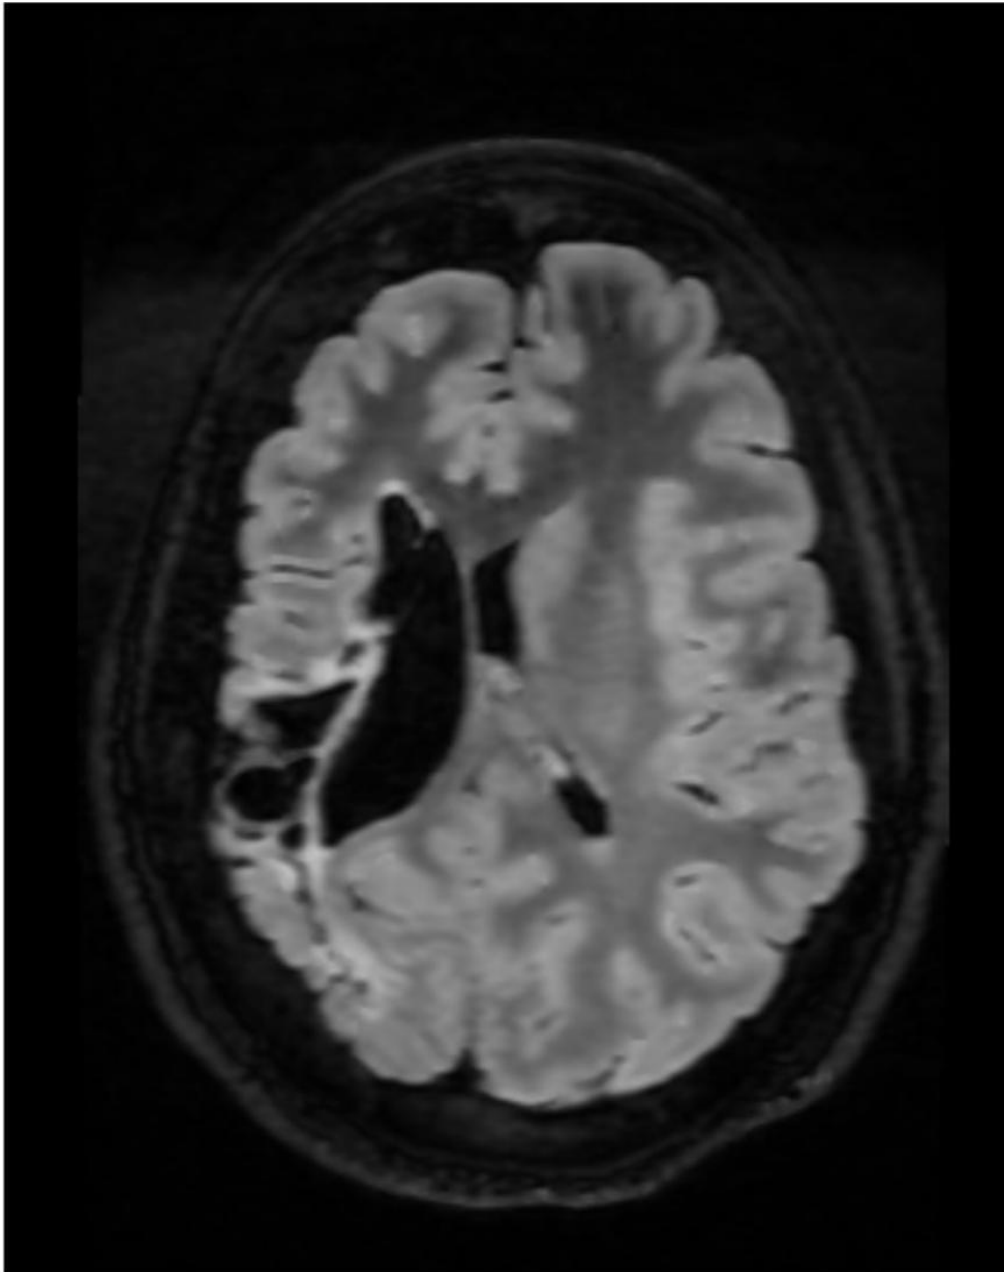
T2-FLAIR axial section MR Image showing right sided cystic encephalomalacia with atrophy of right cerebral hemisphere and midline shift towards right
